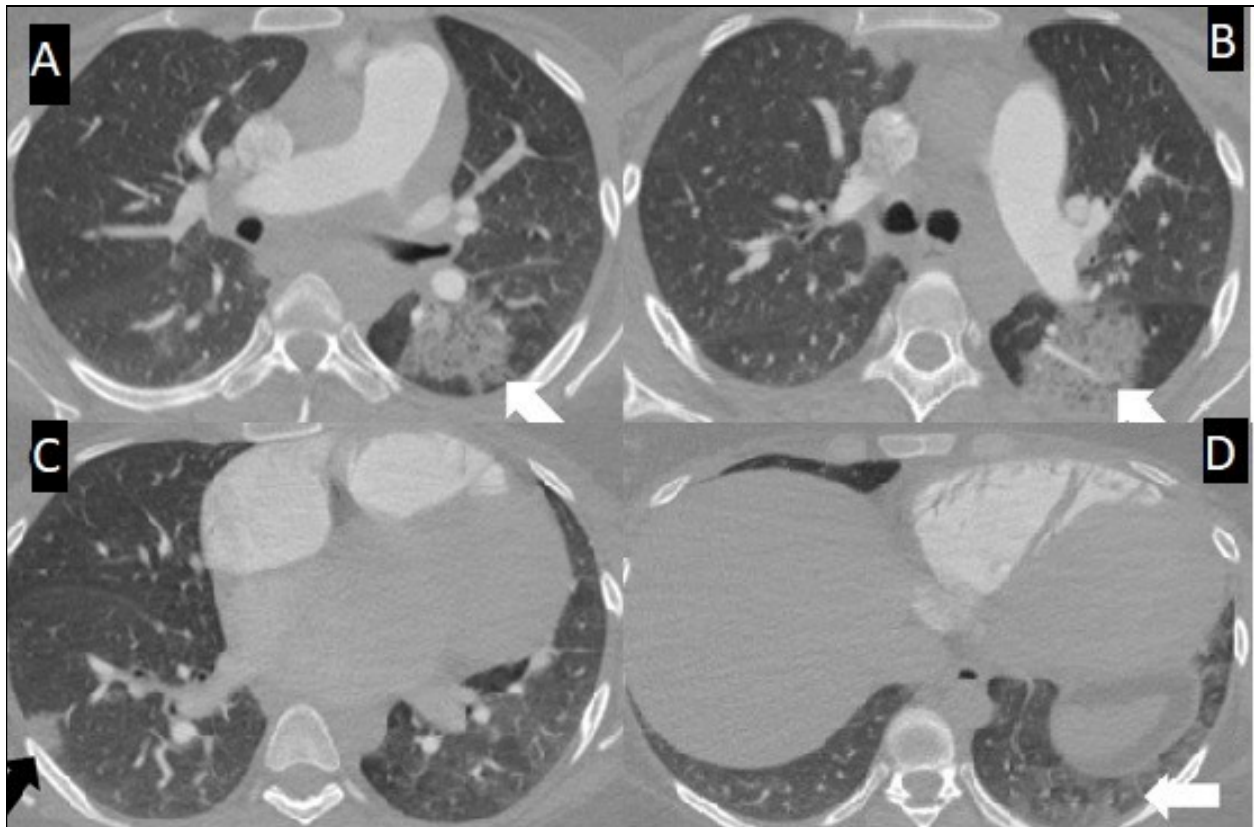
CT scan of the chest. 3A: Left lower lobe consolidation (white arrow), 3B: Left lower lobe consolidation (white arrow), 3C: Right middle lobe consolidation (black arrow), 3D: Left lower lobe consolidation (white arrow).
